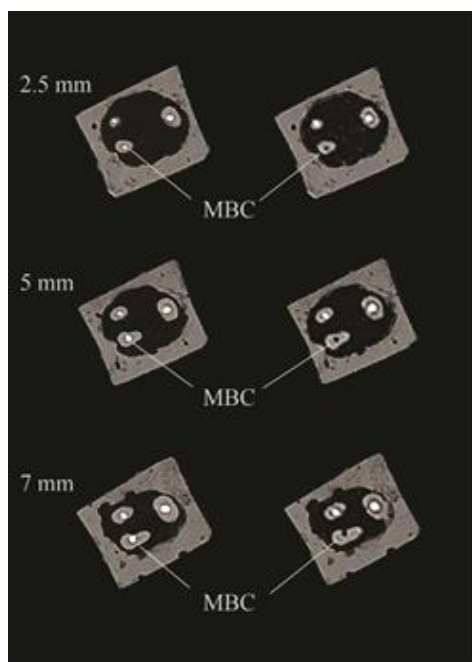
Representative CBCT images before (left) and after (right) gutta-percha removal using Mtwo instrumentation in mesio Buccal canals (MBCs) at 2.5, 5, and 7 mm from the apex
